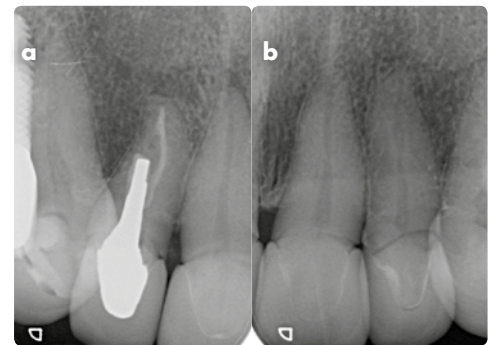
(a) and (b): Plain film radiographs showing upper incisors which were previously intact. Note the taper and outline of the cores showing the volume of sound tooth tissue destroyed for these full coverage ceramic crowns along with the periapical radiolucency at the upper right central incisor and near perforation by the post in the upper right lateral incisor
